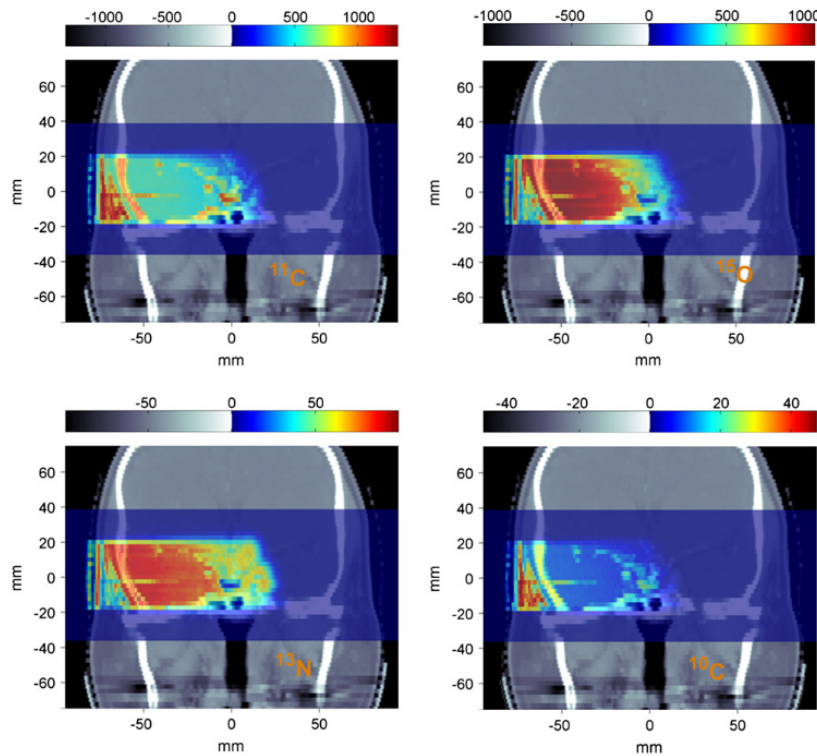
Example of the calculated spatial total β^+ activity concentration produced during 1 Gy proton irradiation of a skull-base tumour. The most abundant β^+ emitters: ^{11}C , ^{15}O , ^{13}N , and ^{10}C , contribute to this total activity. Isotopes concentrations are given in $10^3/\text{ml}$ (colour scale). CT images display in grayscale. Figure adapted from [109]
